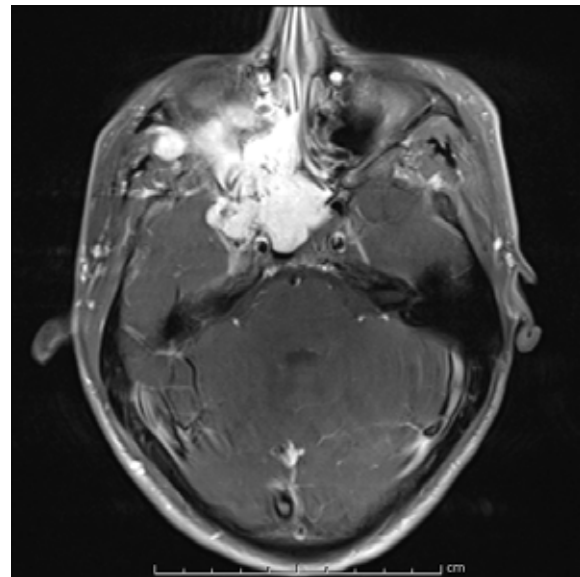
Axial view of CT showing an extensive JNA.
